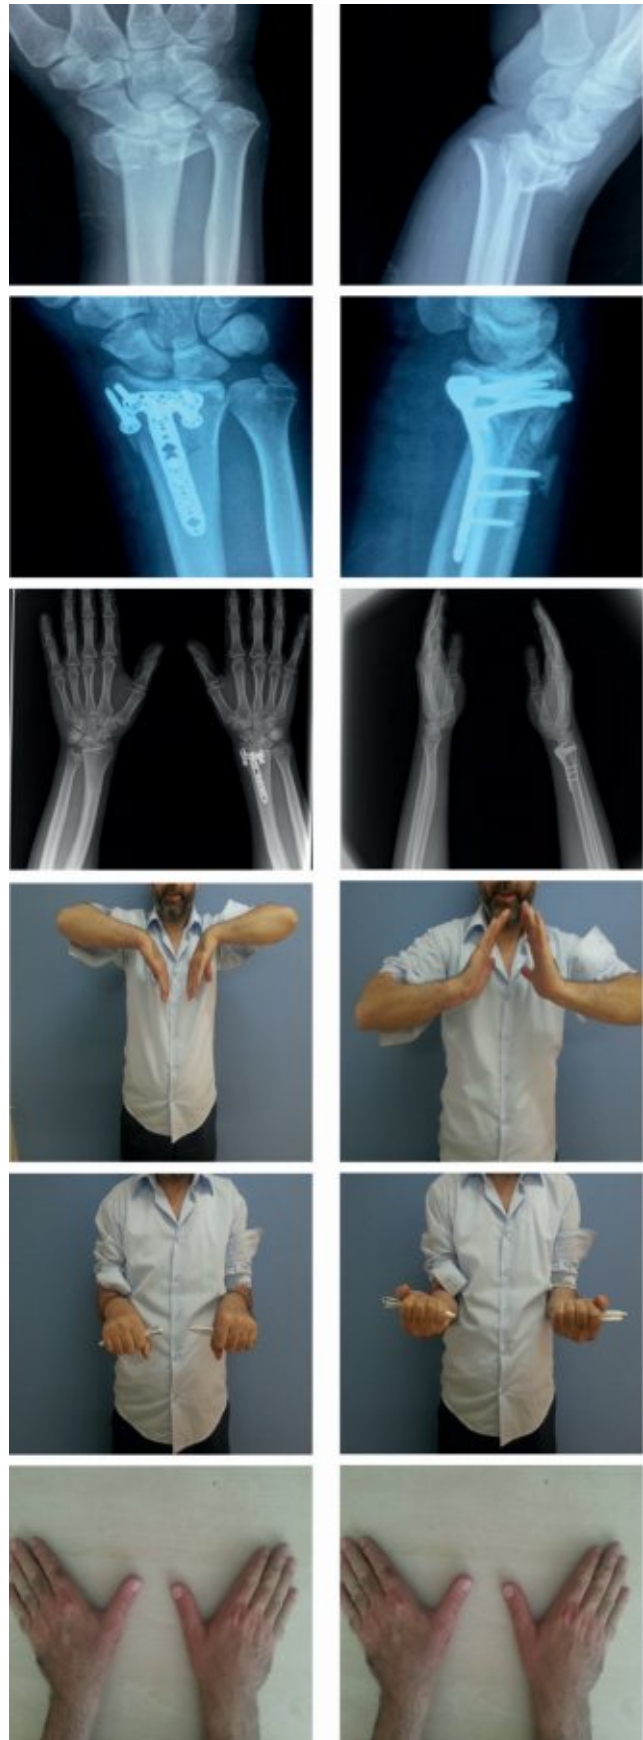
Case No: 6, .E. , age 42, male, AO Type C3.2, before and after surgery, demonstrating the range of motion, with the final control radiography.
